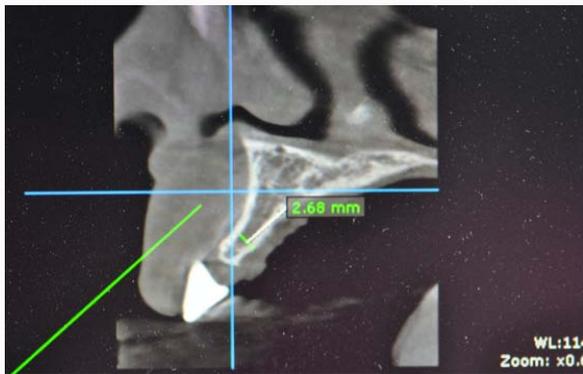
Initial CT scan where the lack of bone thickness is evident to make implants.
